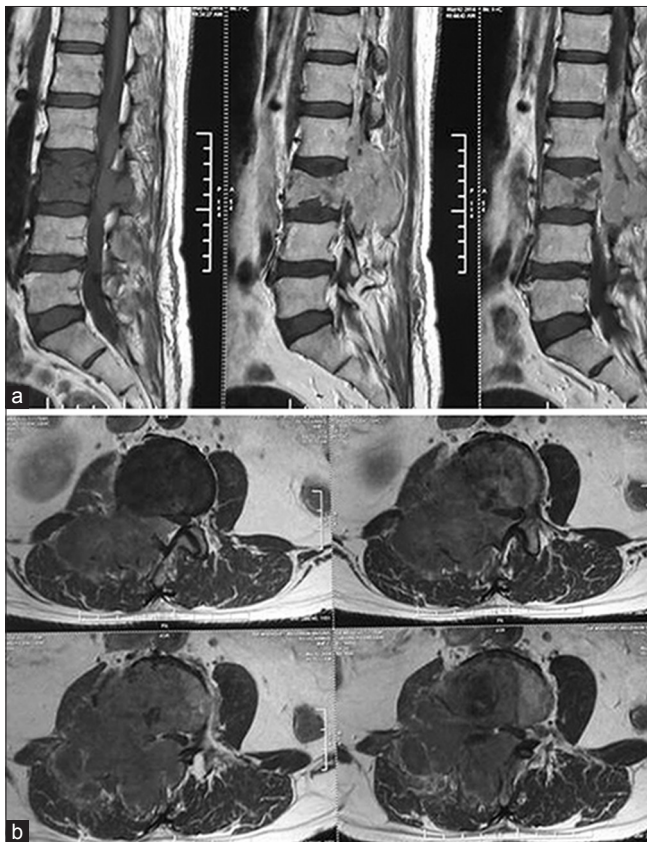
Magnetic resonance imaging sagittal sections (a) showing iso to hyperintense mass lesion involving 3rd lumbar vertebrae with extradural component on axial sections (b) involving the body, pedicles, lamina, and paravertebral soft tissue
